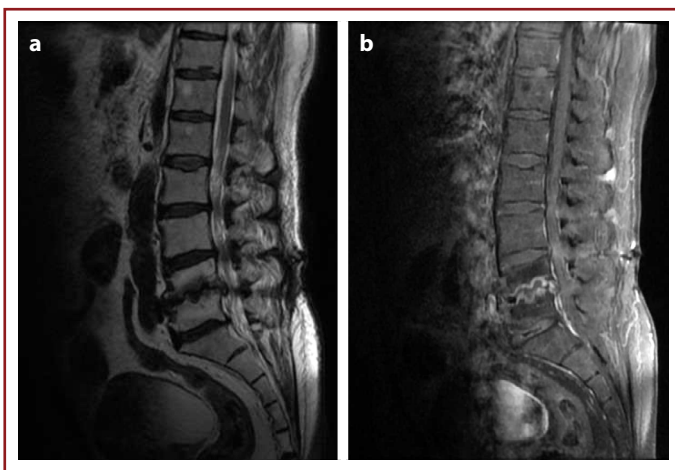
(a, b) Irregularity and discitis in the L4-5 intervertebral area in T2 sequence MRI and contrast-enhanced examinations.
